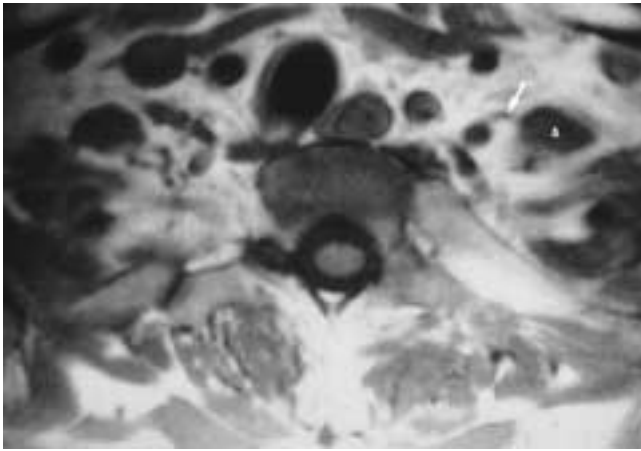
Phrenic nerve. Axial T1-weighted MR image demonstrates the phrenic nerve (*arrow*) medial to the anterior scalene muscle (*A*).
